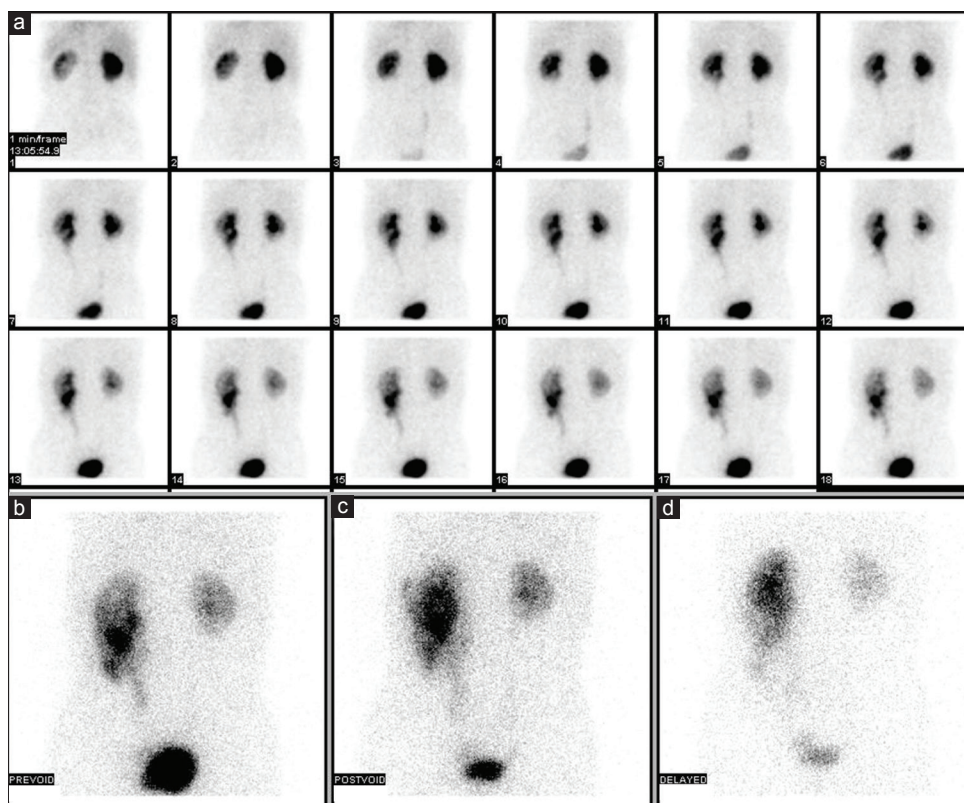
^{99m}Tc-ethylene dicycstine renal scintigraphy shows pooling of tracer in the region of the lower pole of the left kidney in dynamic (a), prevoid (b), postvoid (c), and delayed (d) static images
